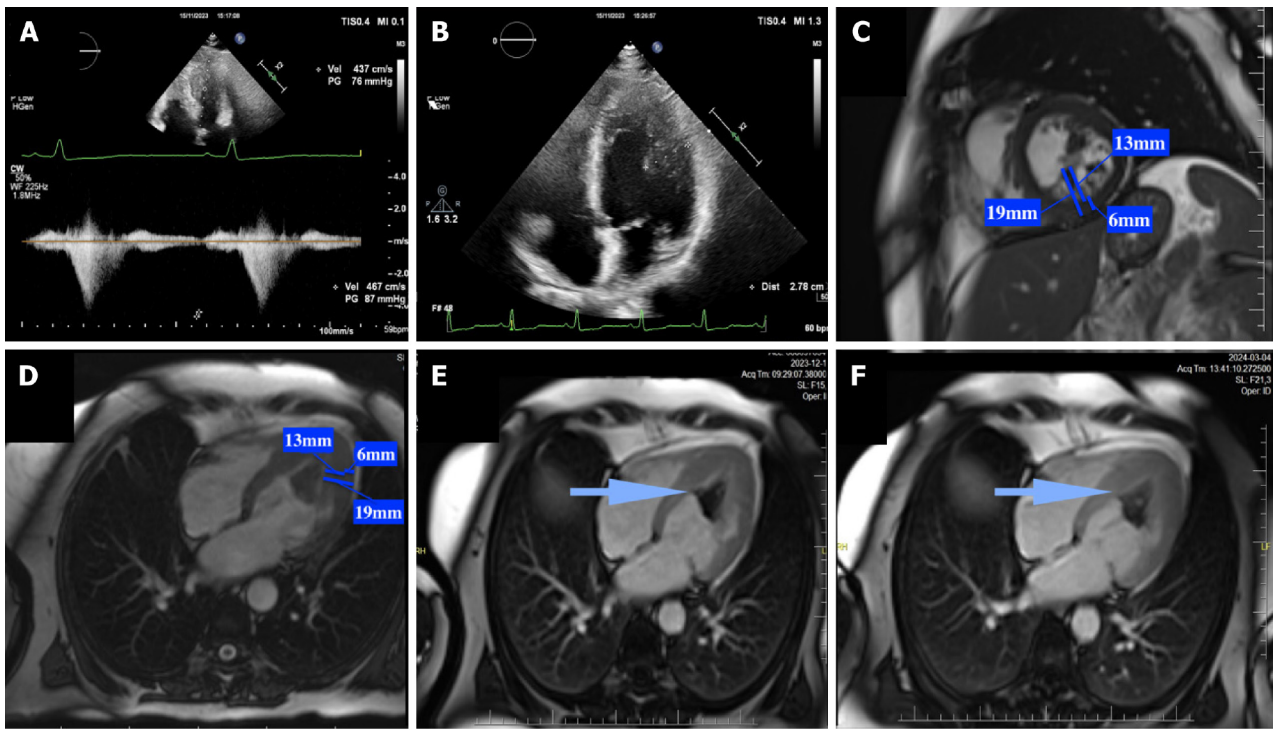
Images from transthoracic echocardiography and cardiac magnetic resonance imaging of a 58-year-old woman with coexistence of left ventricle hypertrophy and hypertrabeculation leading to intracavitary obstruction with heart failure symptoms, and left ventricle thrombus formation with subsequent transient ischemic attack. A: Pulse-wave Doppler from apical 4-chamber transthoracic echocardiography (TTE) view showing intracavitary obstruction at the level of the papillary muscles (maximal resting gradient of 76 mmHg); B: Left ventricle (LV) apical hypertrophy in apical 4-chamber view in TTE; C and D: LV hypertrabeculation in cardiac magnetic resonance short axis view and 4-chamber view (ratio of thickness of non-compacted to compacted layers 2.1: 13 mm and 6 mm); E and F: LV thrombus entering between the LV trabeculae and recesses in short axis view and 4-chamber view (blue arrow).
